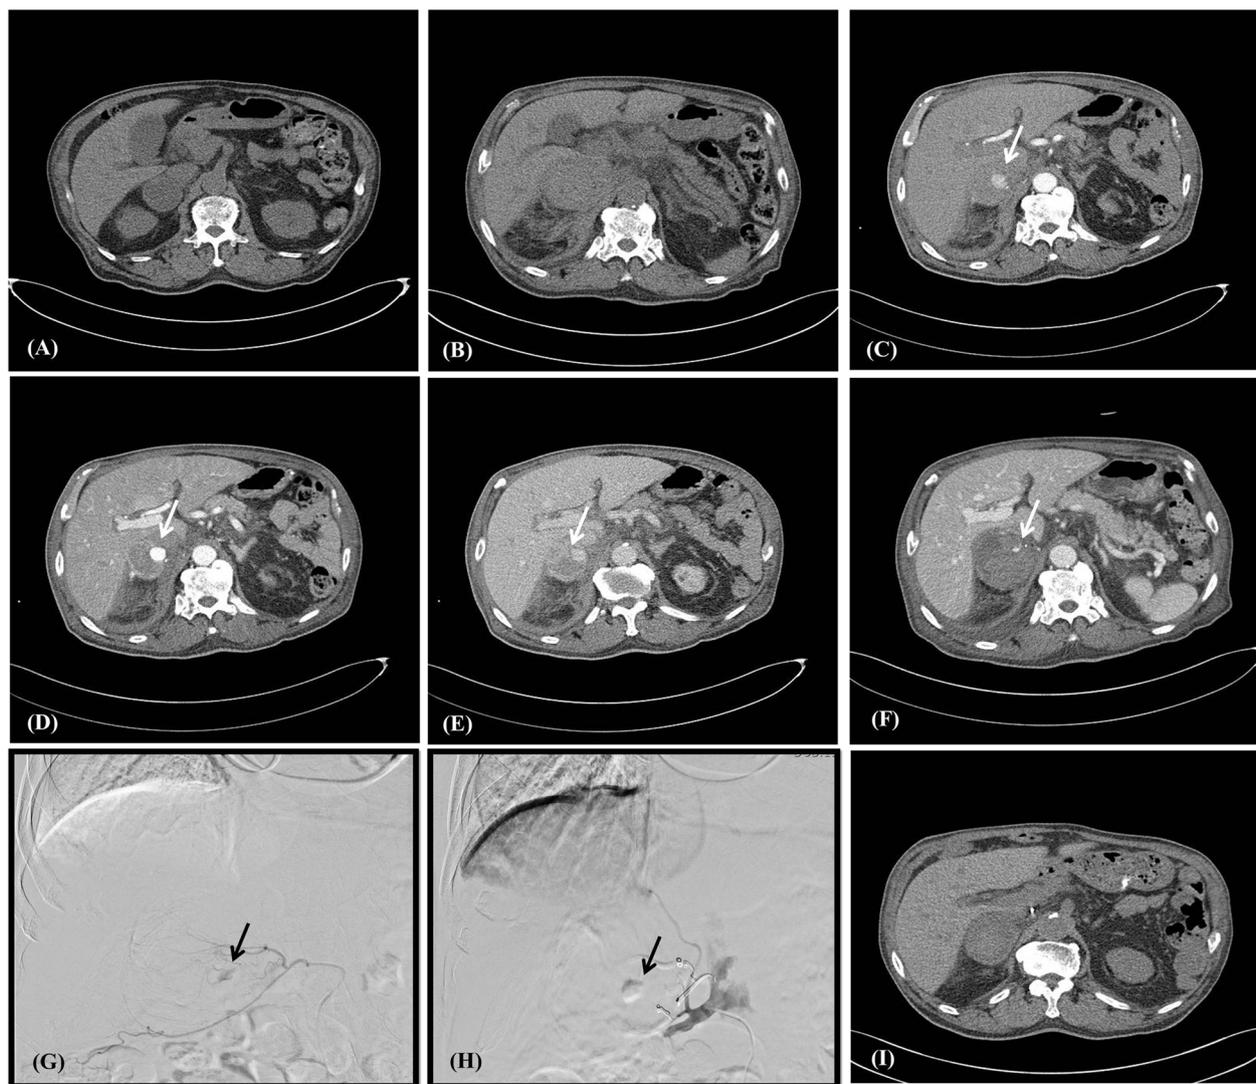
One year ago, an abdominal CT showed a 4.2×4.3 cm-sized right adrenal adenoma, which was a homogeneous mass with 10 HU (a). On the day of admission, and abdominal CT revealed perihepatic, mesenteric, and retroperitoneal hemorrhages and an increase in the size of the adrenal mass, relative to the CT that was performed 1 year ago. The size of the adrenal adenoma increased from 4.2×4.3 cm to 5.5×5.8 cm which included, with aneurysmal formation with contrast
